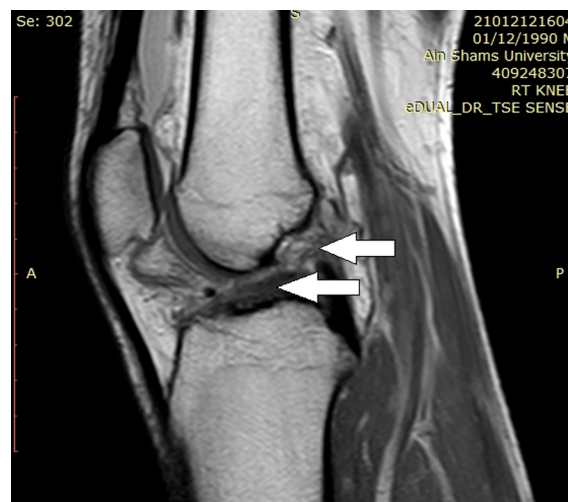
Sagittal PDW knee MR image demonstrating a complete tear of the ACL with surrounding adhesions (arrows).
